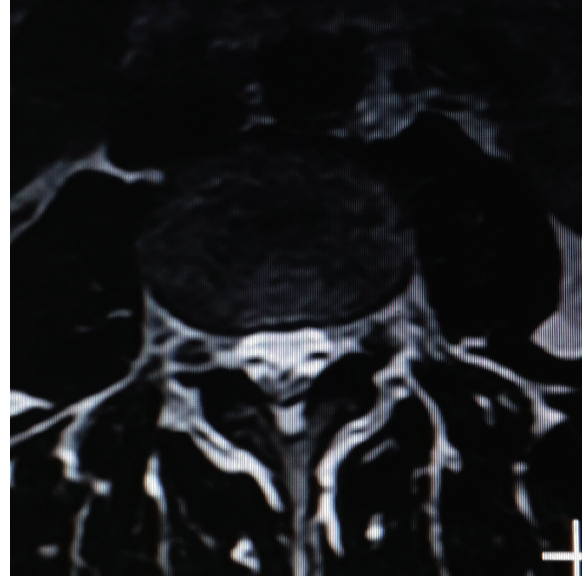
Axial T2-weighted second round MRI showed almost complete regression of the herniated nucleus pulposus at the L4-5 level without nerve root compression
